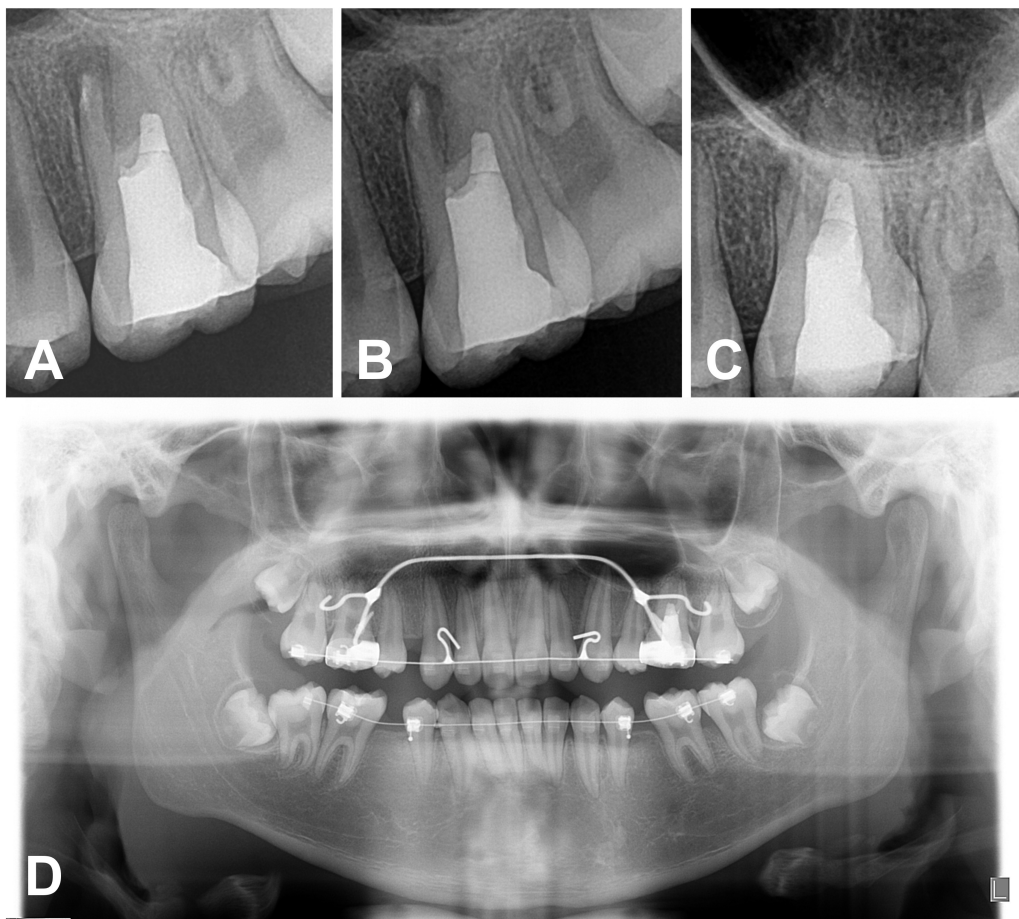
Serial postoperative radiographs. (A) Periapical radiograph following root canal treatment. (B) Periapical radiograph at the 3-month recall. (C) Periapical radiograph at the 1-year recall, showing a calcific barrier directly beneath the mineral trioxide aggregate (MTA). (D) Panoramic radiograph at 5-year and 6-month recall. The radiographs revealed no remarkable findings, and the patient remained asymptomatic.
